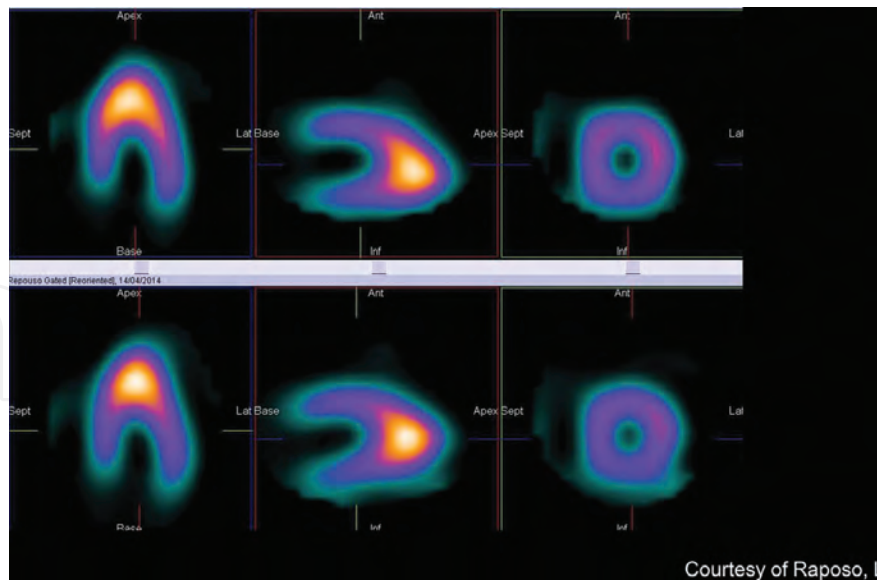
Functional imaging of ischemia with single photon-emission computed tomography (SPECT) with Tc-99m-Sestamibi in a 34-year-old male patient with HCM with history of chest pain in the absence of epicardial coronary artery disease). Stress (upper row) and rest (lower row). A fixed, non-reversible defect (scar) in the basal segments of the LV was found, with a non-coronary artery distribution. The apical perfusion is normal. However, this pattern may be a false perfusion defect due to increased hypertrophic mid-ventricular and apical uptake of the radiotracer. (Reprinted with permission from Cardim et al. [38]).
